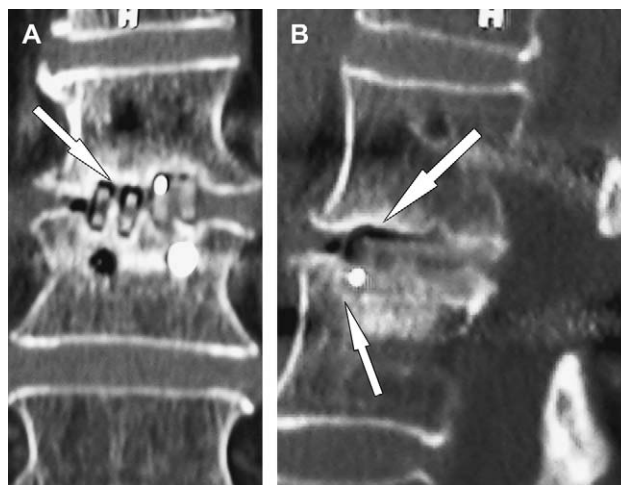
(A) Patient 8, a 73-year-old woman with previous L3–S1 healed fusion, has nonunion of L1–L2. Coronal computed tomographic reconstruction reveals lucency surrounding both interbody cages at L1–L2. (B) Sagittal computed tomographic reconstruction: superior arrow demonstrates lucency around the cage, and inferior arrow shows subsidence into L2 body. Metallic dot in the disc space is the cage position marker.
